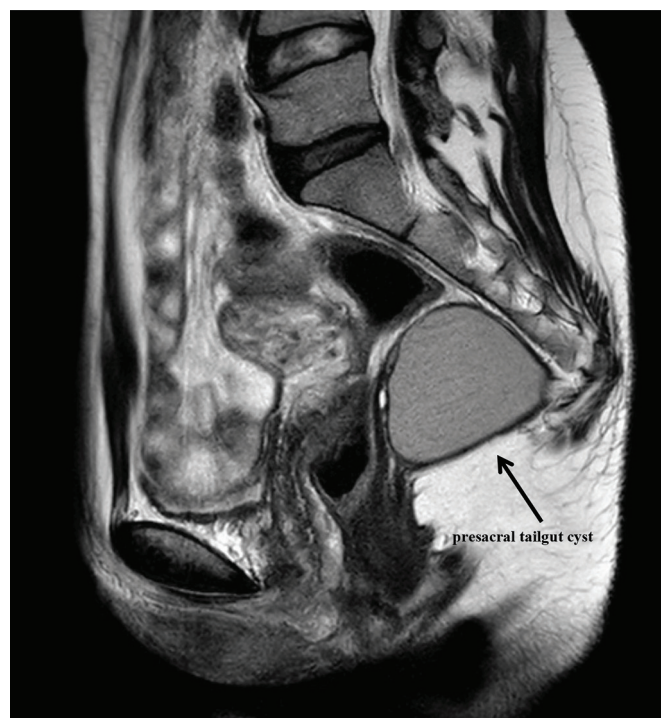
Magnetic resonance image (Patient 5).
